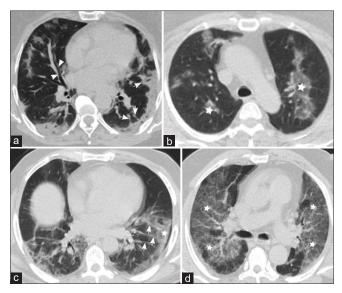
Axial noncontrast chest computed tomography of other features of coronavirus disease 2019 observed in this study. (a) Subpleural traction bands with architectural distortion (arrowheads), and bronchial wall thickening (arrowheads); (b) Nonperipheral patches of ground-glass opacity (stars); (c) Vessel dilatation (arrowheads) within ground-glass opacity (star); (d) Extensive ground-glass opacity and consolidation (ARDS (Acute Respiratory Distress Syndrome) like) (stars)
